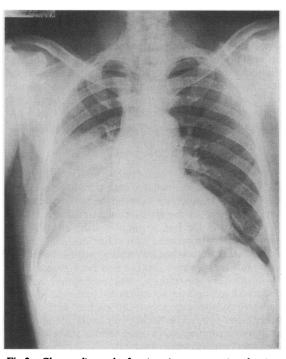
Chest radiograph of patient 4 at presentation showing mid and lower zone consolidation.
